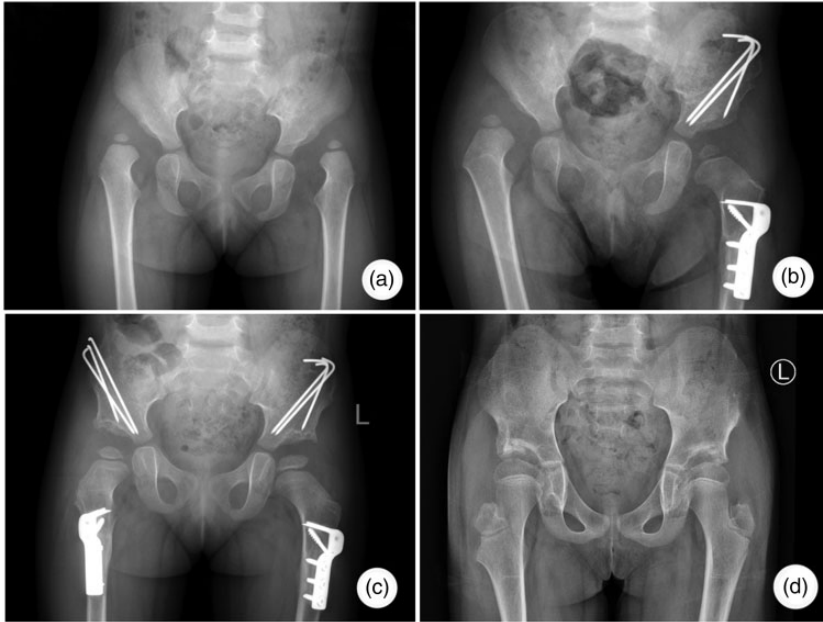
(a) Anteroposterior pelvic radiograph of a girl aged 2 years and 1 months shows equal Tönnis grade III dislocation with bilateral developmental dysplasia of the hip. (b) Open reduction and Salter osteotomy combined with shortening osteotomy were performed on the left side at 2 months of follow-up. (c) A similar surgical procedure was performed on the contralateral side 6 months later. (d) Radiograph 7 years after the operation shows type I according to the Severin classification on both sides.
